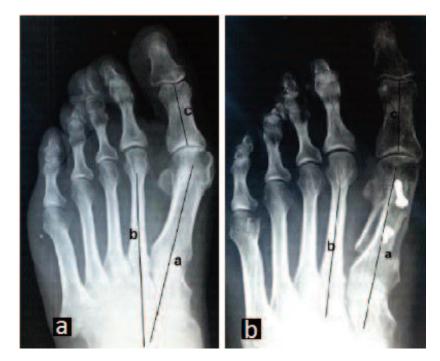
Scarf osteotomy. Preoperative radiograph of the foot of a 41-year old female patient with HVA 30° and IMA 16° (a). In the same patient, at postoperative 5 months, a decrease of HVA 11° and IMA 5° can be seen (b). HVA = Hallux valgus angle (HVA), IMA = Intermetatarsal angle
